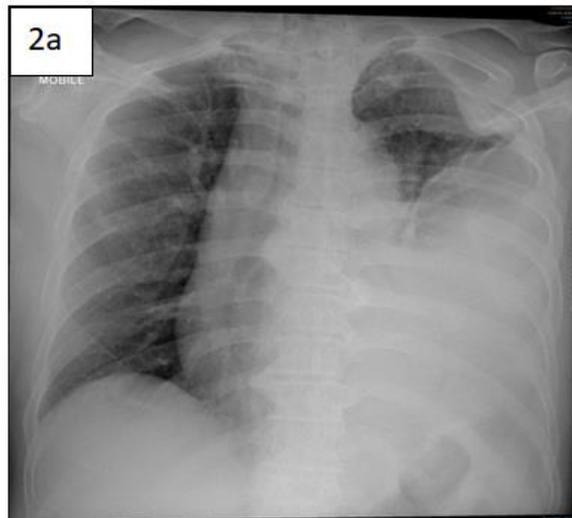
Pre operative chest x-ray showing a massive left sided effusion pleural effusion
